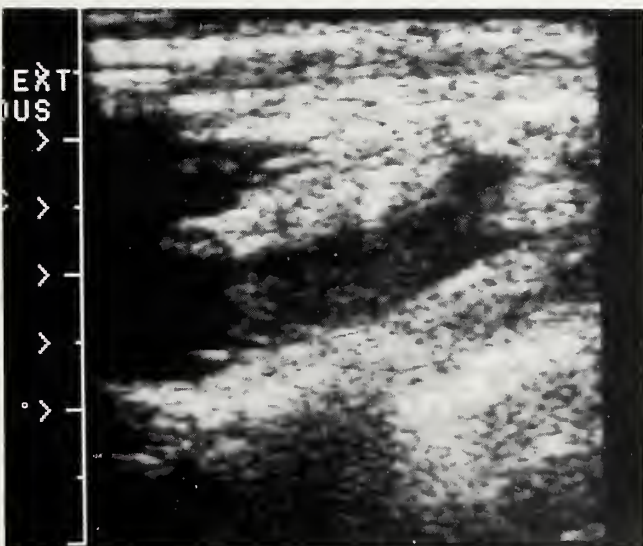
Ultrasound study documenting an extensive thrombus in the left subclavian vein.
